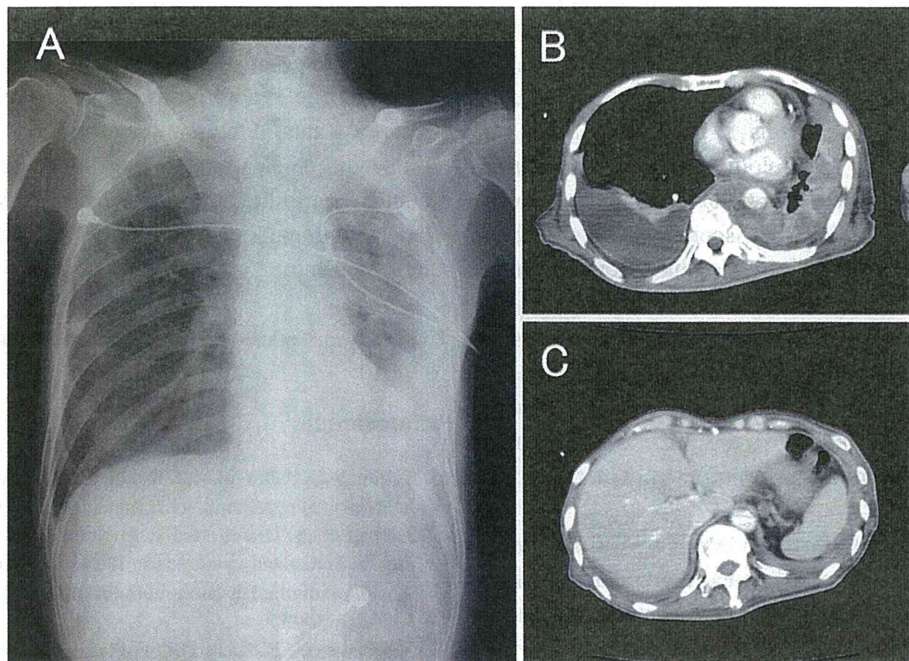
Chest radiography (A) and computed tomography of the chest (B) and abdomen (C) performed on the second admission showing a left pleural tumor, right pleural effusion (likely due to nephrotic syndrome), ascites and left adrenal metastasis.
